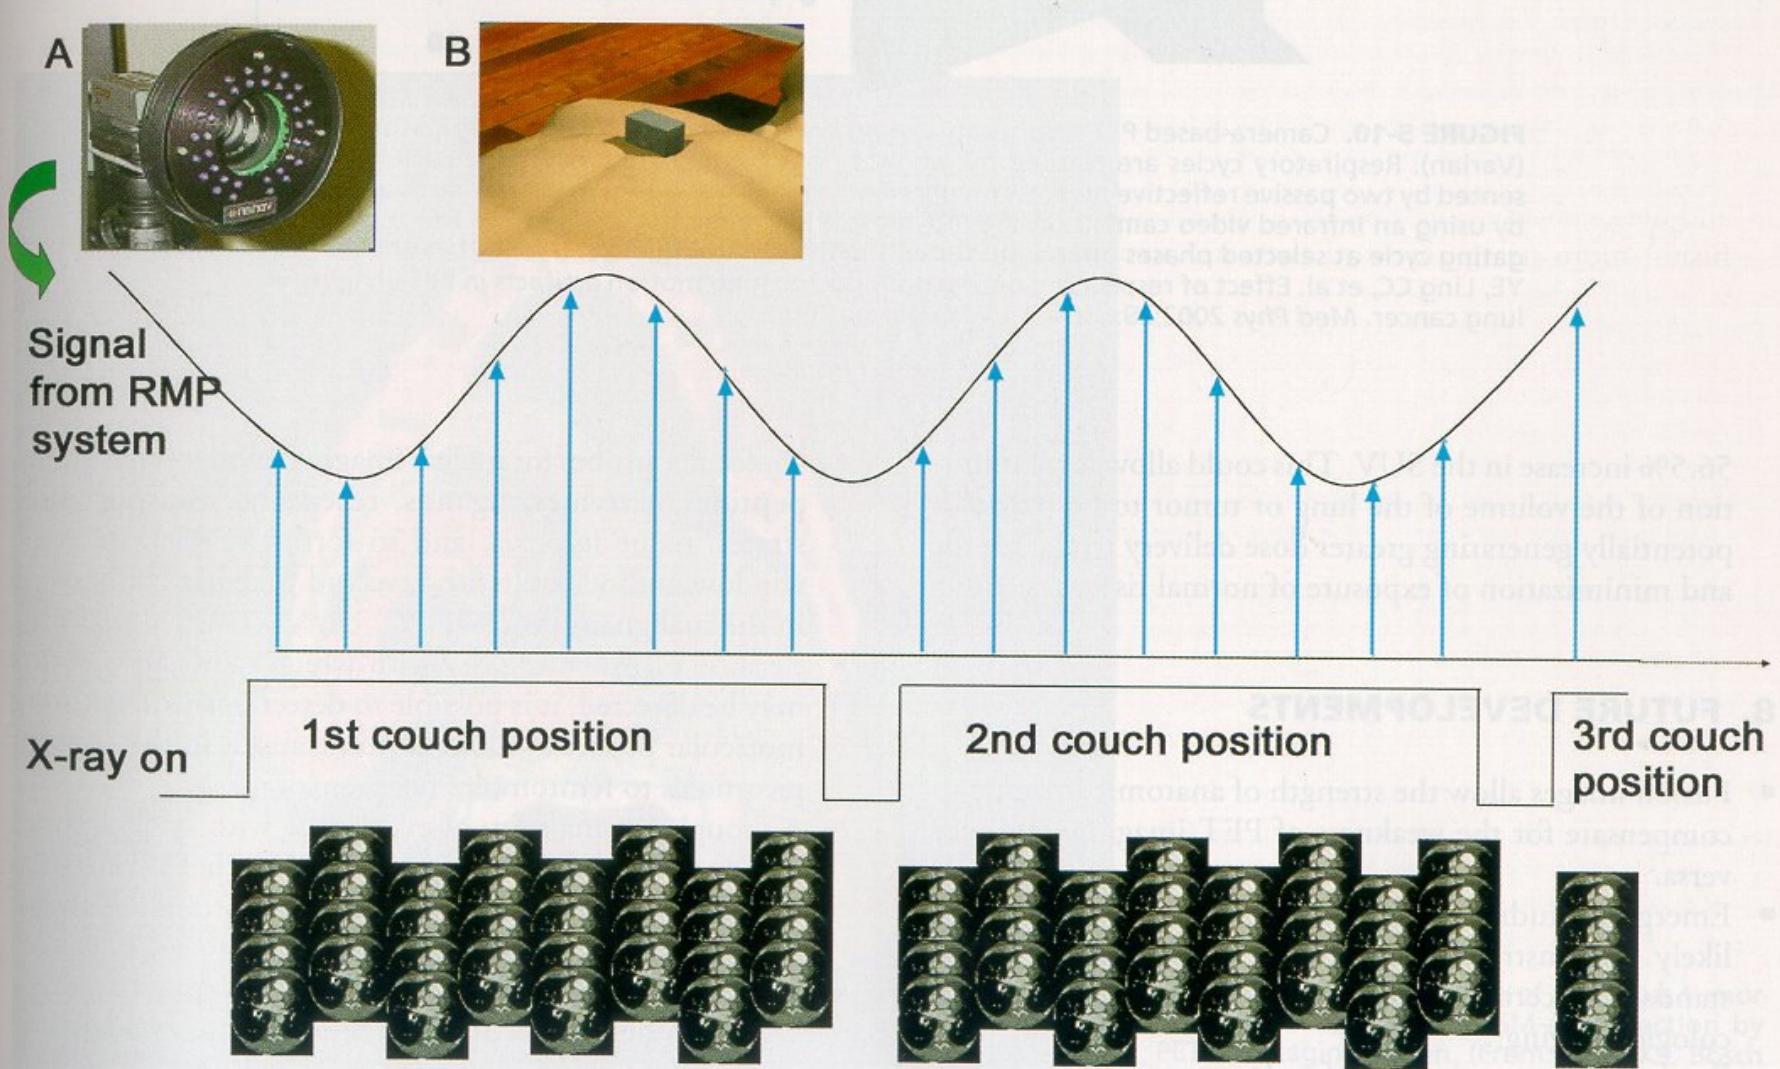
Four dimensional (4D)-CT respiratory motion tracking with retrospective gating. Respiratory motion is tracked by following a block mounted on the patient's chest (B) with a Varian (Cary, NC, USA) real-time position management (RPM) optical monitor (A). CT images are acquired at end-tidal inspiration and expiration over complete respiratory cycles.
